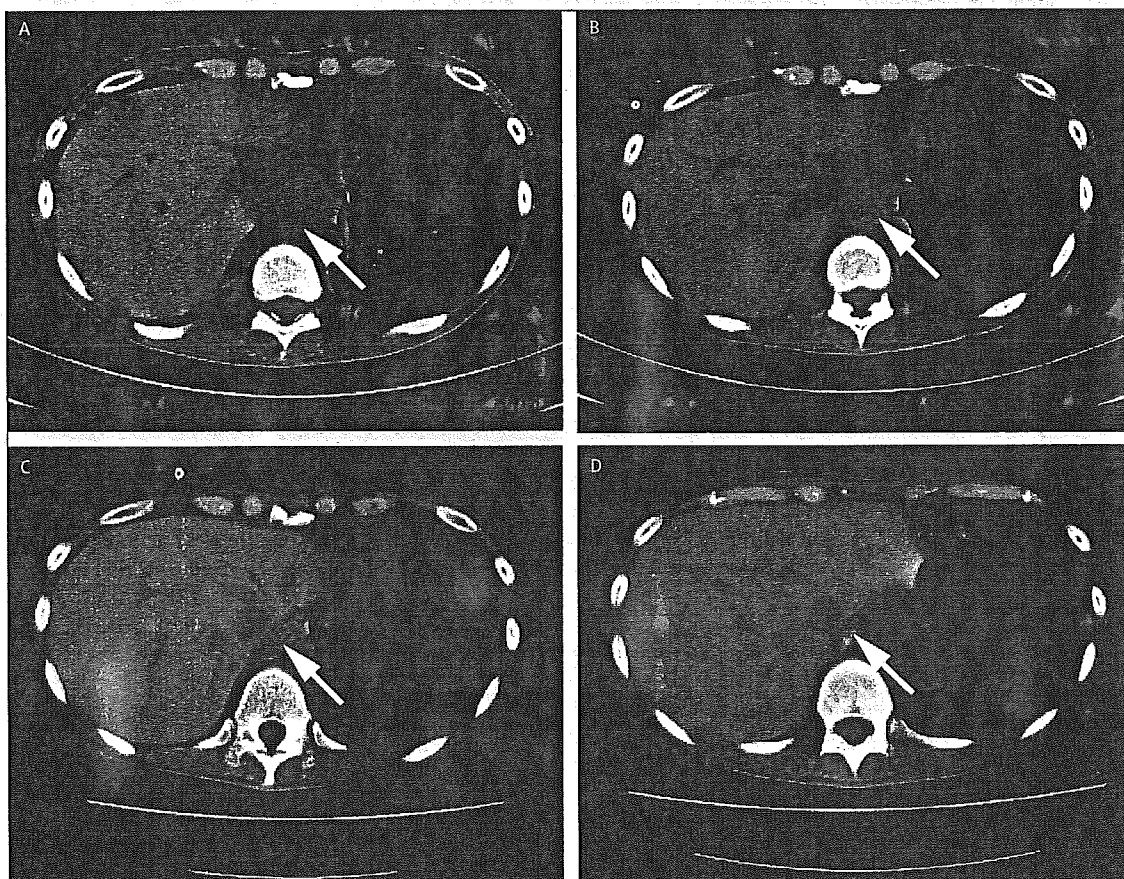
CT scans of retrocrucl mass (arrows) before transplantation (A; 58×37 mm), and 12 days (B; 46×22 mm), 38 days (C; 33×13 mm), and 171 days (D; 21×9 mm) after transplantation
